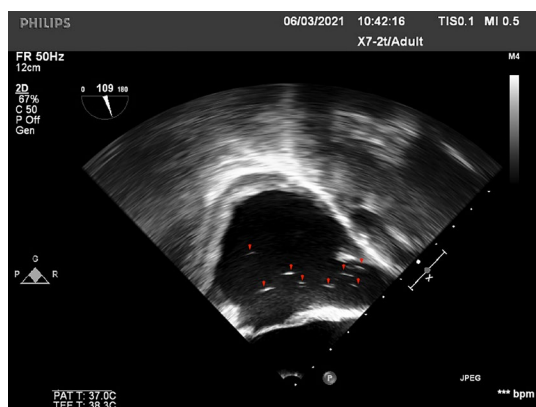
The esophageal ultrasound suggests the presence of persistent bubbles in the superior vena cava and right atrium. The arrows show bubble echoes. FR, frame rate; 2D, two-dimensional; PAT, patient apparent temperature; TEE, transesophageal echocardiography.
